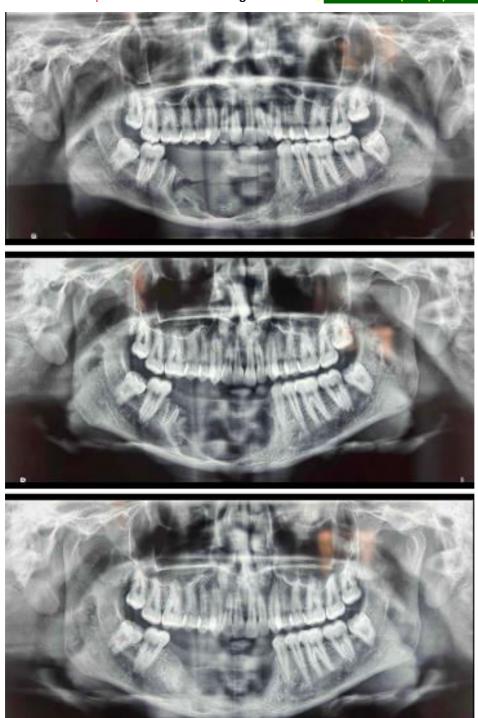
Followup Orthopantomograms at 3 months interval
